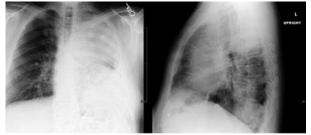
A chest x-ray shows left lower lobe infiltrate and loculated effusion within the left upper lobe.
